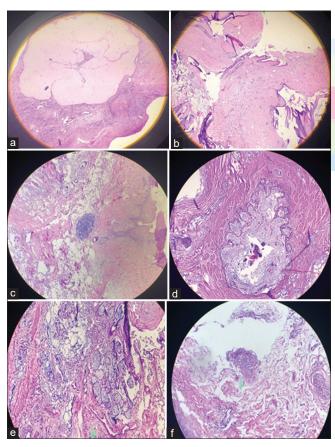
(a) Normal Ovarian tissue with Corpus albicans. (b) Skin. Keratinized stratified squamous epithelium (epidermis) and a fibroelastic connective tissue layer (dermis) with adnexal structure such as Sebaceous gland and Sweat glands. (c) Mature hyaline cartilage. (d) Respiratory type of epithelium. Pseudostratified columnar epithelium with Mucin secreting glands. (e) Intestinal type of epithelium with simple columnar epithelium. (f) Hair follicle The transvaginal ultrasound results [Figure 1] were equivocal, hence diagnostic laparoscopy with possible oophorectomy and frozen section was contemplated.
